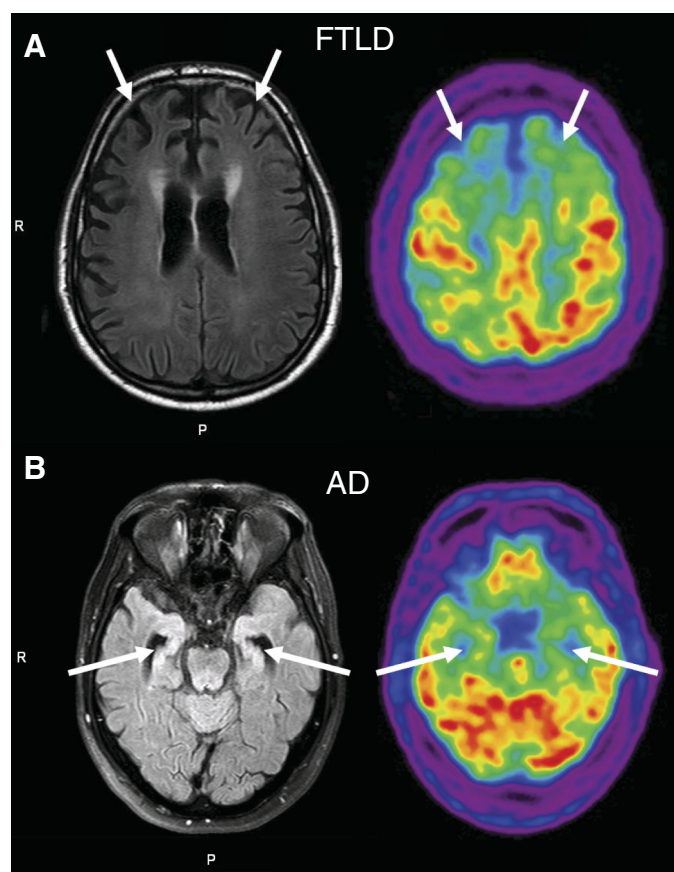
Typical brain imaging of FTLD and AD patients. Magnetic resonance imaging and functional imagery (F-18 FDG PET scan) of one typical frontotemporal lobar degeneration (FTLD) patient, with frontal lobes impairment (A, patient FTLD5), and of one typical Alzheimer's disease (AD) patient, with medial temporal lobe impairment (B, patient AD9).
